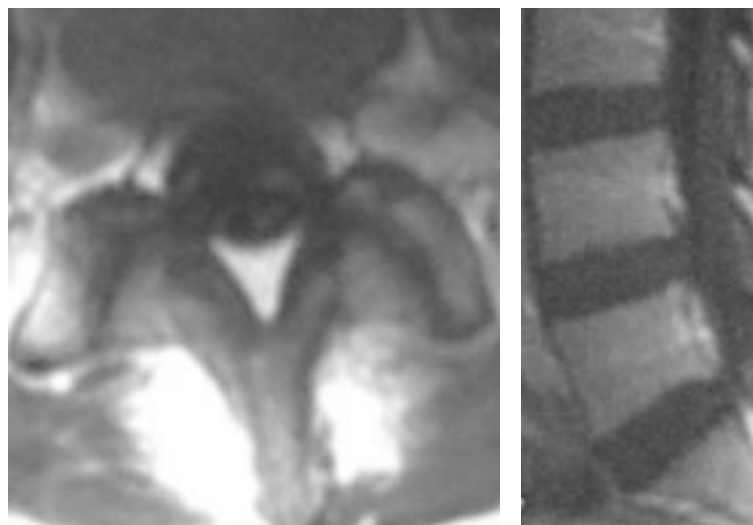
One month later, after treatment, repeat MRI showed that the enhancement in the cauda equina had almost completely resolved.
